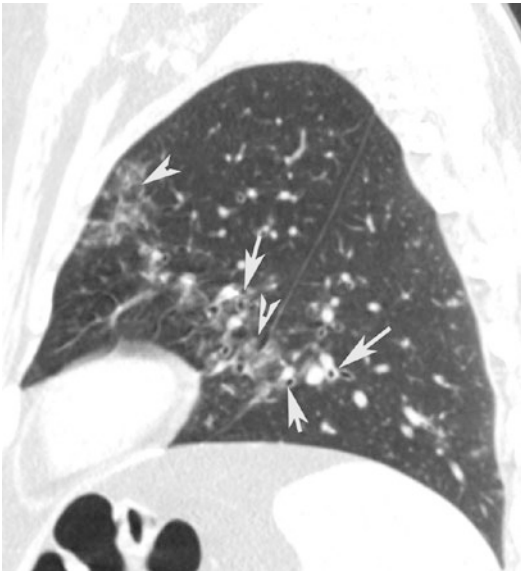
Peribronchovascular nodules. CT sagittal scan shows small nodules (*arrow tips*) in the bronchovascular bundle and peribronchial inflammation (*arrows*)
